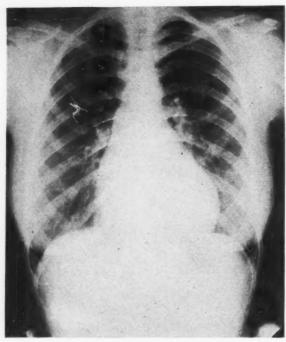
Case XIII. Roentgenogram; pulmonary stenosis with ventricular septal defect.
